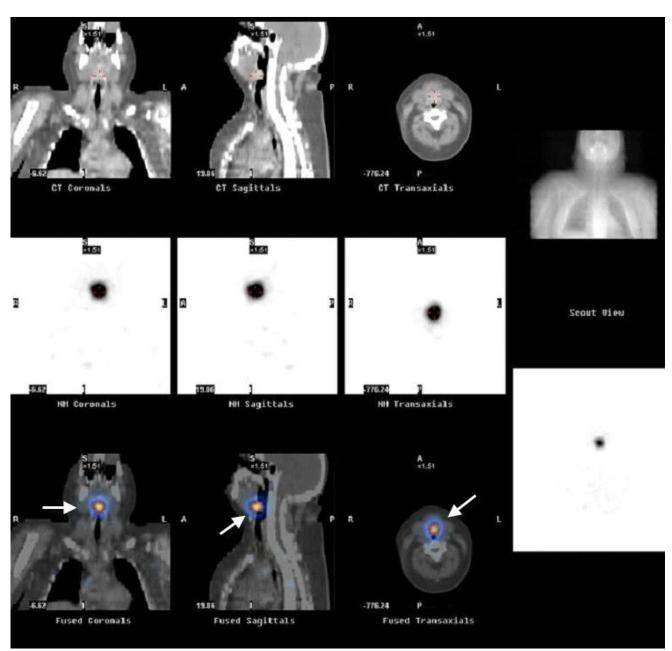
48-year-old white female with obstructive lingual thyroid. SPECT-CT showing the pre-treatment lingual thyroid. Focal radioiodine uptake evident on SPECT localizes on fused SPECT/CT images to the midline base of tongue mass, confirming lingual thyroid. SPECT/CT images were performed approximately 24 hours after ingestion of 285 microcuries (10.5 MBq) 123Iodine using GE Hawkeye Infinia SPECT/CT camera.
